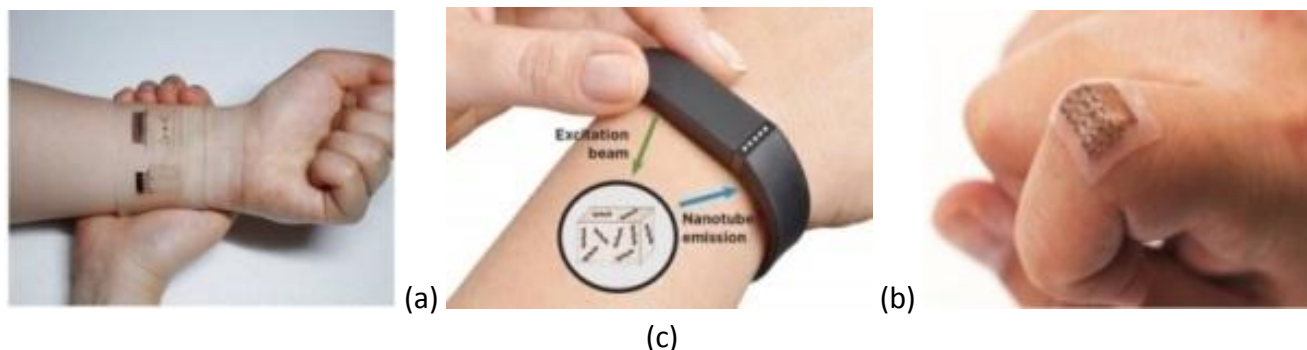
(a) Graphene wristband sensing blood sugar levels, (b) wearable cancer monitors, (c) wearable ultrasound patch tracks blood pressure in a deep artery or vein.
